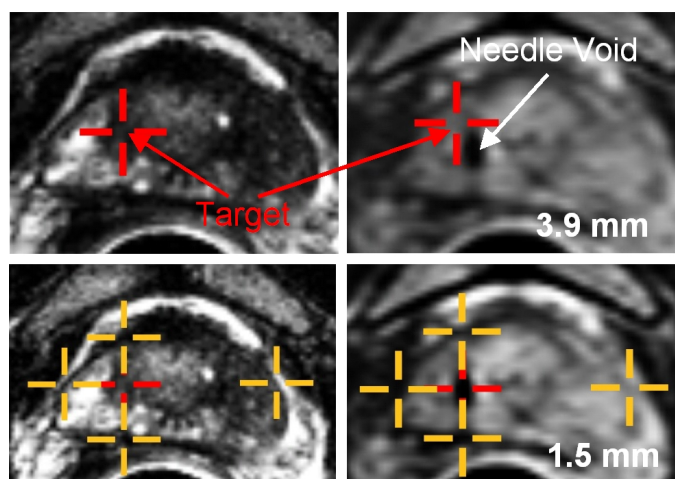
Targeting image and needle confirmation image of second clinical procedure using the APT II system. Top left: Suspicious target (red cross hairs) was selected on axial TSE T2-weighted images. Top right: The needle tip void was visualized in axial TSE proton density images. Error number in top right image: The number indicates the in-plane targeting error for the needle placement of 3.9 mm. This high placement error is a result of motion of the prostate and the APT II rectal sheath, which occurred sometime in between obtaining the targeting image and confirmation image. The borders (bottom row, yellow cross hairs) of the prostate were used to calculate a 2D anatomical error. The 2D anatomical error is defined as the difference in distance of the target location to the left-right, and top-bottom prostate border on the targeting image (bottom, left) to the distance of the center of the needle void to the left-right, and top-bottom prostate border on the confirmation image (bottom, right). Error number in bottom right image: The number indicates the 2D anatomical error for the needle placement of 1.5 mm.
